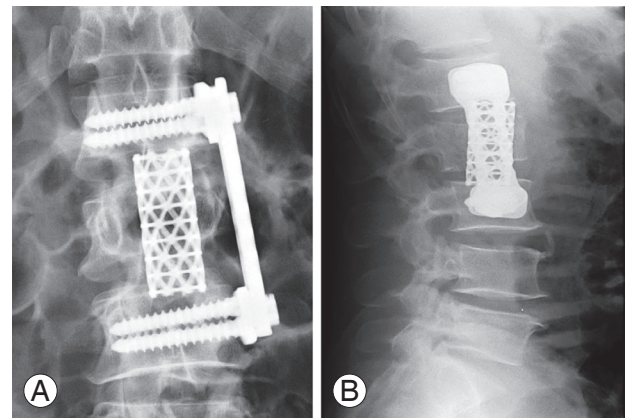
(A, B) Postoperative X-ray of the retroperitoneal approach for L2 fracture.
